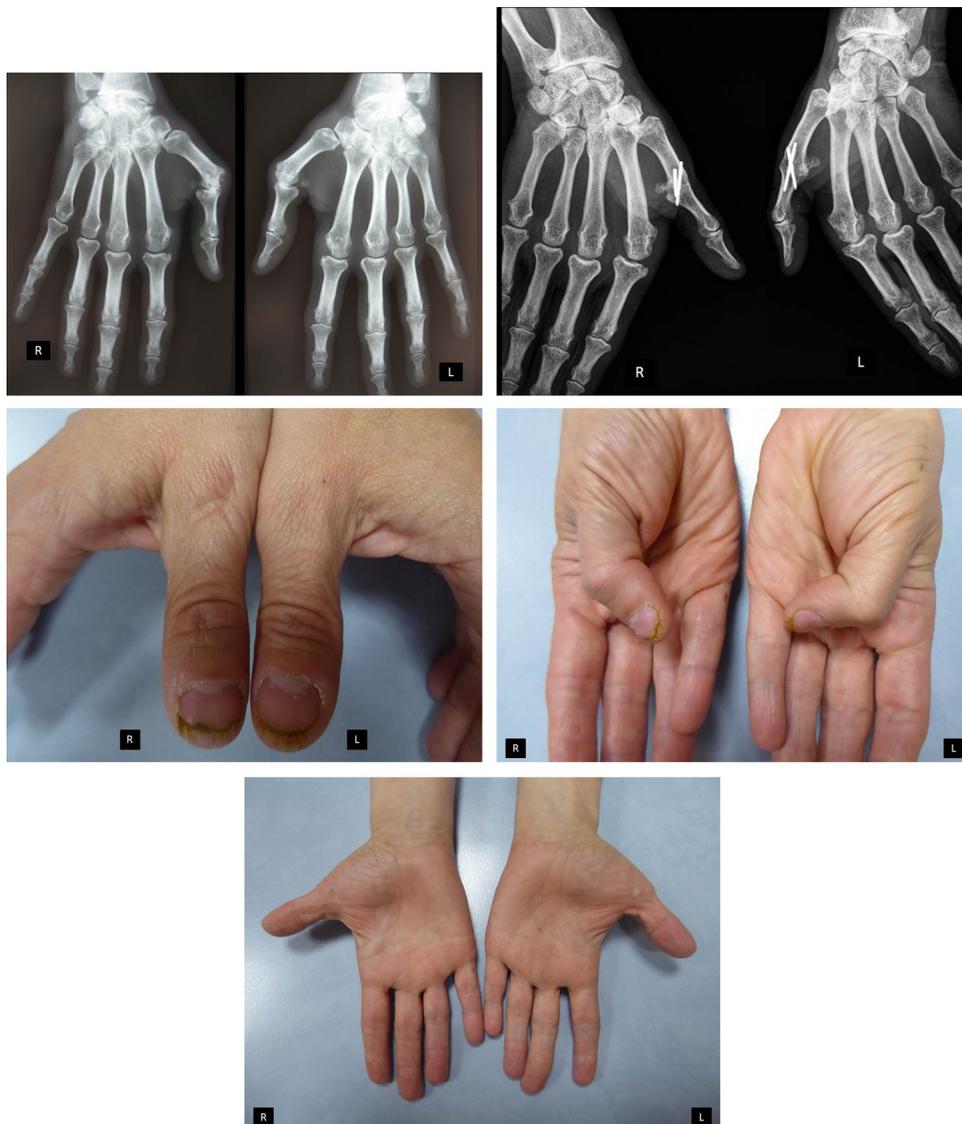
Clinical case in a patient with rheumatoid arthritis. Conventional open technique on right hand. Minimally invasive technique on left hand. X-ray before surgery (A). X-ray after surgery (B). Scar after surgery. On right hand, the scar is large with some adhesions; on left hand, the scar is invisible (C). Motion after surgery. On right hand, opposition is limited (Kapandji score at 8); on left hand, opposition is better (Kapandji score at 9) (D). Motion after surgery. Opening of the first web space is the same in both hands (E).
